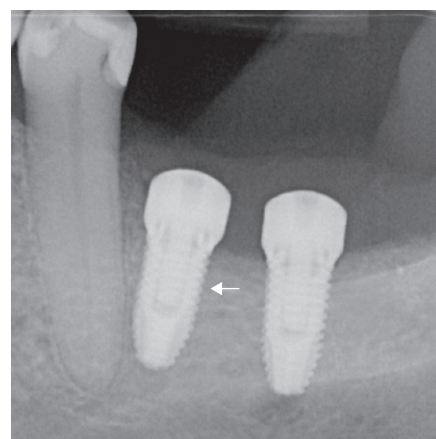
Incorrect technique: wrong position of the film and/or non-perpendicular orientation of the X-ray.
